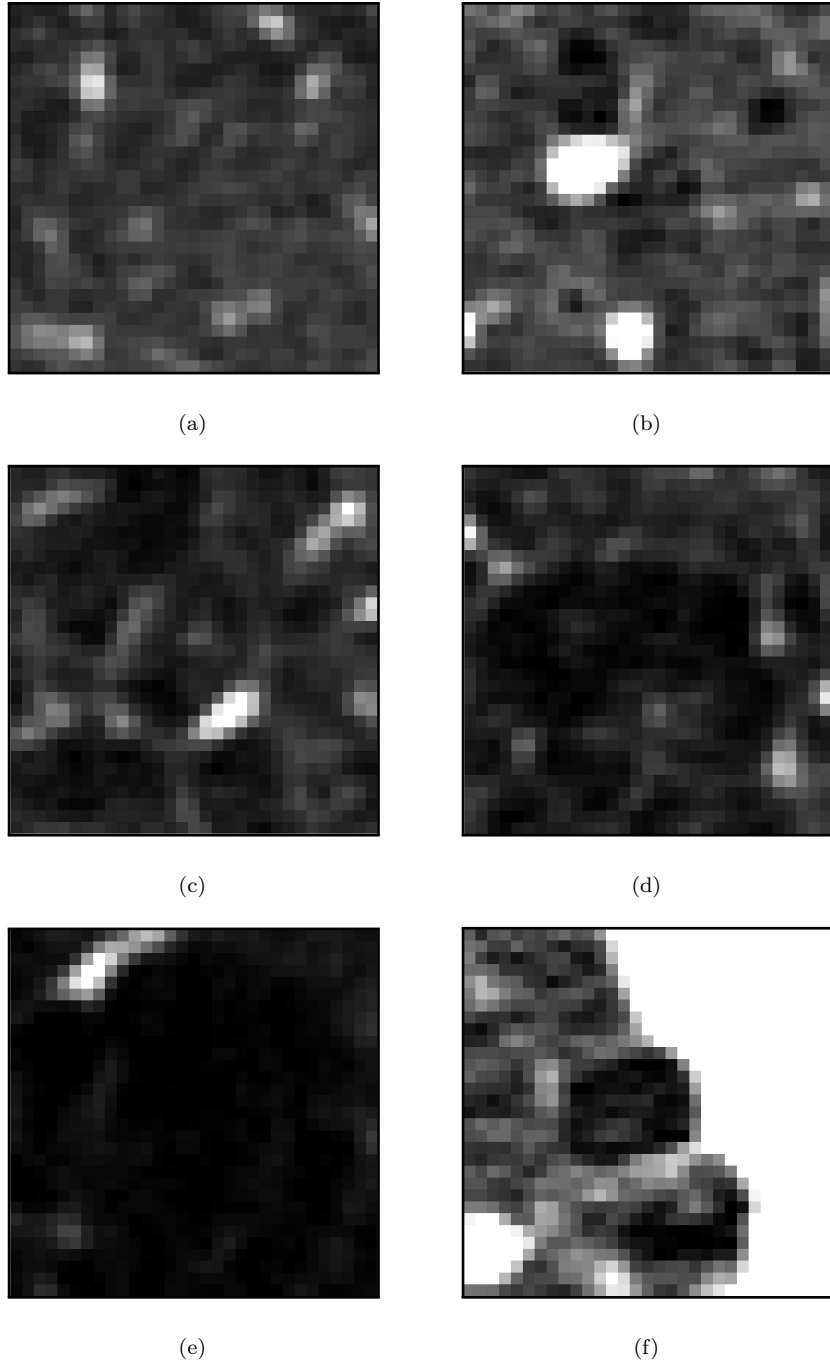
Examples of emphysema regions of size $24.18 \times 24.18 \text{ mm}^2$, extracted from real CT scans, in the window $[-1000, -500]$. (a) Healthy tissue. (b) Mild centrilobular emphysema. (c) Moderate centrilobular emphysema. (d) Severe centrilobular emphysema. (e) Panlobular emphysema. (f) Paraseptal emphysema
